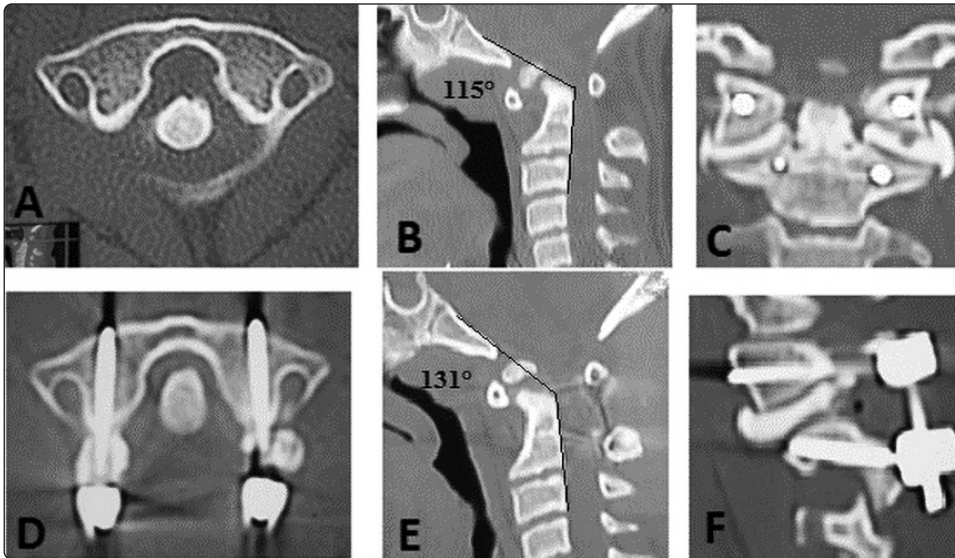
Pre- and postoperative CT scan of (patient no. 1). (A) Preoperative axial view of atlas with atlantodental interval = 6 mm; (B) preoperative sagittal view showing the encroachment of the craniocervical junction and clivus-canal angle; (C) postoperative coronal view revealing the bone cement at the facets bilaterally; (D) postoperative axial view of atlas showing the bicortical screws purchase and reduced atlantodental interval = 2 mm; (E) postoperative sagittal view noting the reduced dens and clivus-canal angle; (F) parasagittal view at the facet joint showing the bone cement at the facets.
